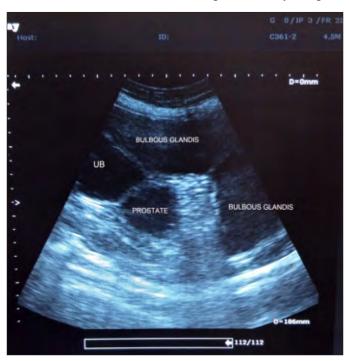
Ultrasonographic appearance of enlarged bulbous glandis characterized by hypoechoic to mixed echogneic structures characterization of transmissible canine venereal tumor. Rev Port. Cienc. Vet. 102: 253-260.
